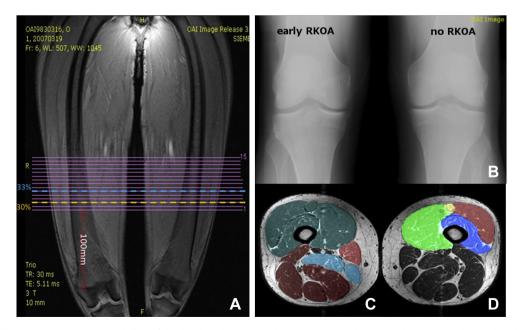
A. Coronal localizer image: 15 continuous axial slices of the thigh have been acquired. B. Participants (right top). For the current study we selected participants with early RKOA in one knee and no RKOA in the contralateral knee on fixed-flexion X-rays (right top). C–D. Axial cross-sectional MRIs with segmented muscles. ACSAs of the quadriceps (pink), hamstrings (red), and adductors (yellow) have been segmented at 33% of femoral length (from distal to proximal) (C). ACSAs of the individual quadriceps heads vastus medialis (brown), vastus intermedius (turquoise), vastus lateralis (yellow), and rectus femoris (purple) have been segmented at 30% of femoral length (from proximal to distal) (D).
